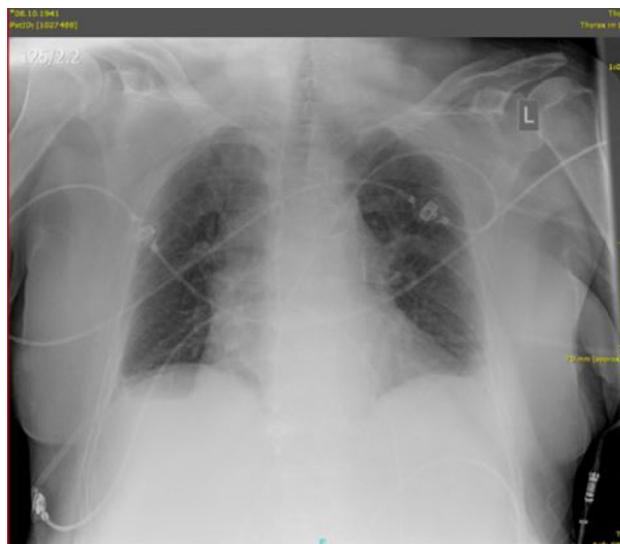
Chest X-ray at hospital admission
